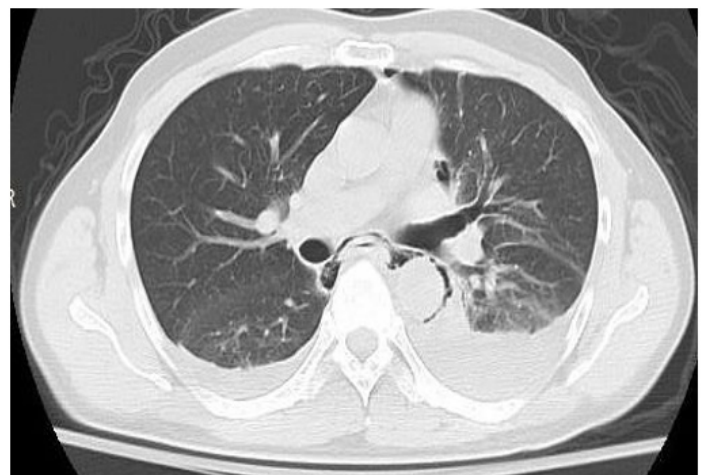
Thoracic CT demonstrated mediastinal air without pleural effusion.
